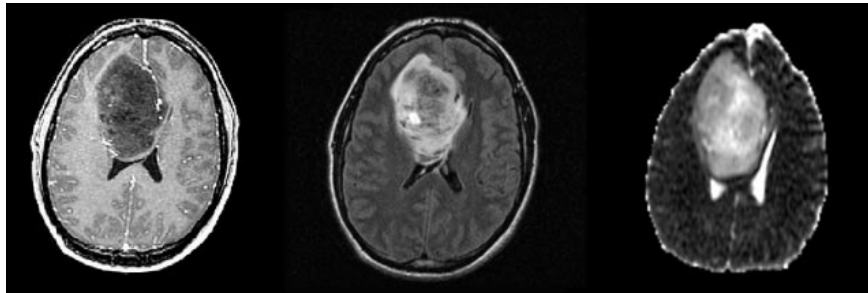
DWI scans of different WHO grades astrocytomas. (Left) WHO grade II, Middle) WHO grade III, (Right) WHO grade IV astrocytomas (Image from Cha, 2006).
